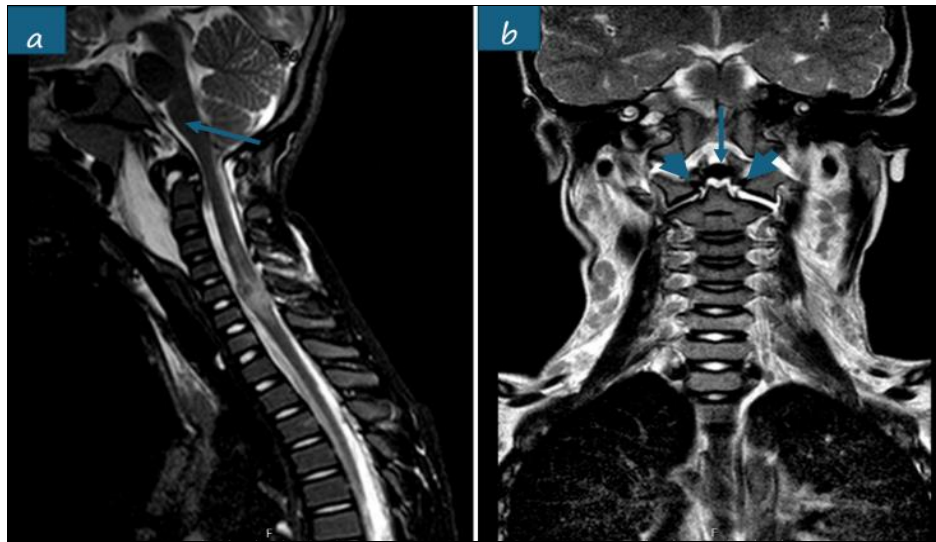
a) Sagittal cut of MRI presence of retroclival hematoma, b) Arrow indicates lesion of tectorial membrane, arrow head indicates lesion of alar ligaments
